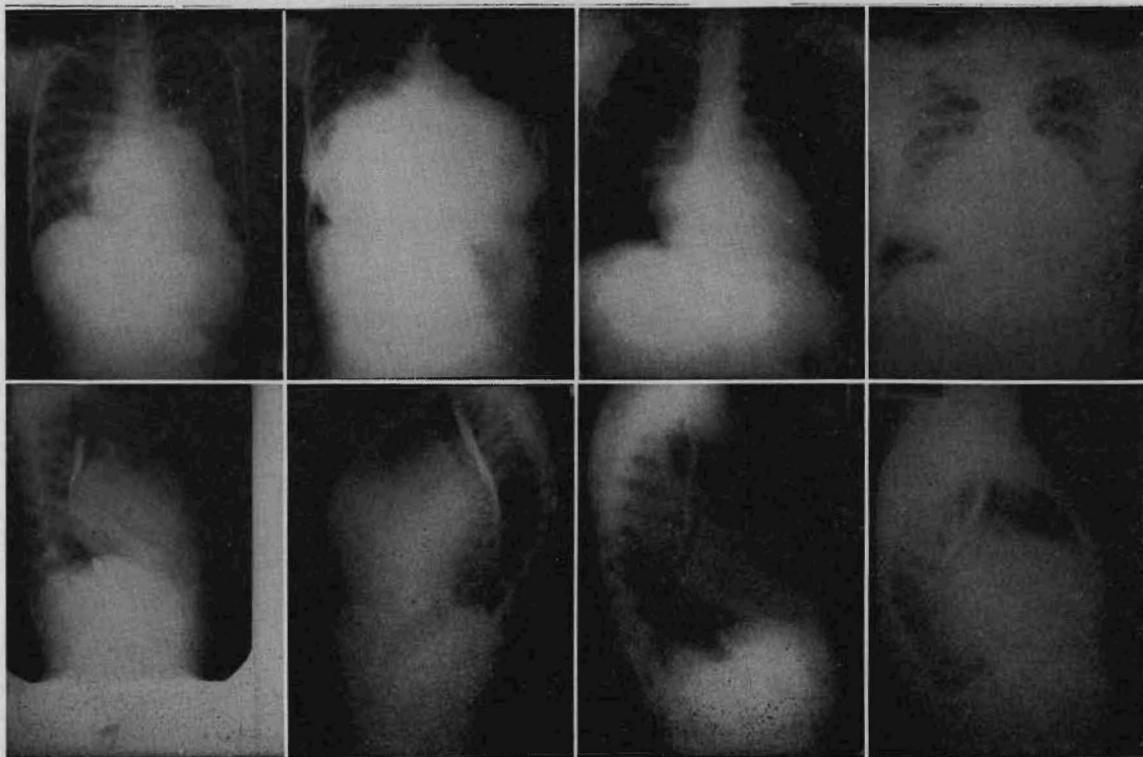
Preoperative chest x-rays of cases 1, 3, 4, 5. A.P. film above and lateral film below.
